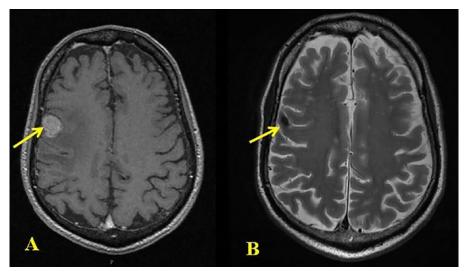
(A) MRI lesion in brain and (B) MRI lesion responding completely to TKI. MRI indicates magnetic resonance imaging; TKI, tyrosine kinase inhibitor.
